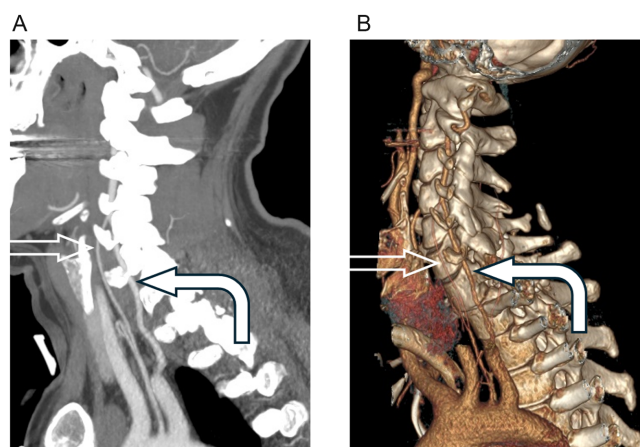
(a) Sagittal oblique CT angiogram showing the left anterior branch (empty white arrow) and left posterior branch of the vertebral arteries (curved white arrow); (b) 3D reconstruction of the left vertebral artery after gunshot injury.
